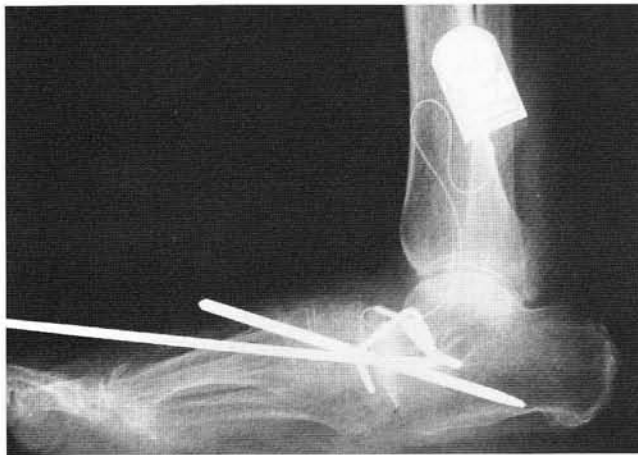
Immediate postoperative radiograph. Procedures included revisional midtarsal joint arthrodesis and naviculocuneiform arthrodesis with Steinmann pin fixation. A tendo Achillis lengthening was also performed. The bone stimulator's cathode wire can be noted at the midtarsal joint fusion site. The generator with its anode are implanted in Kagar's triangle.
